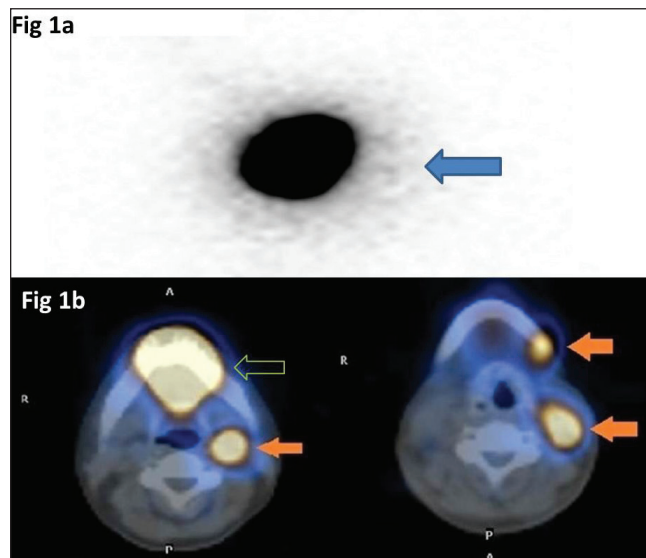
Detection of more sentinel nodes on SPECT as compared to planar imaging. (a) shows planar lymphoscintigraphy with injection site (blue arrow); no hotspots are seen. SPECT/CT scan done in the same patient is shown in (b) showing the injection site (hollow arrow) and three hotspots at left cervical levels IB, II, and III (red arrows)
